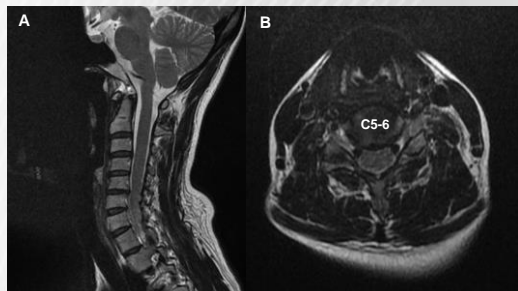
Spine MRI : Sagittal T2 weighted image (A); Axial T2 image (B) at C5-6 level showing right-sided mild subarticular protrusion.
